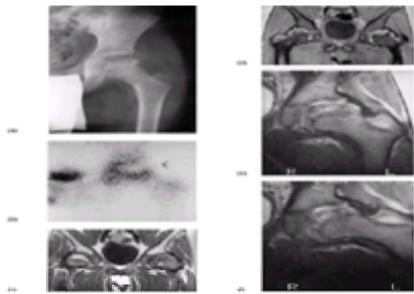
Legg–Calvé–Perthes' disease involving the left hip in an 8-year-old boy. (a) Radiograph shows a typical fragmented appearance of the femoral head with lateral loss of containment. (b) Bone scan shows a decreased uptake in the necrotic bone. (c) T_1 -weighted MR image shows the extent of necrosis (arrow). (d) Gradient-echo image shows the cartilaginous containment of the femoral head and the extent of the osteolytic area. (e–f) T_2 -weighted MR images, without and with abduction, guide the femoral or pelvic osteotomy.
